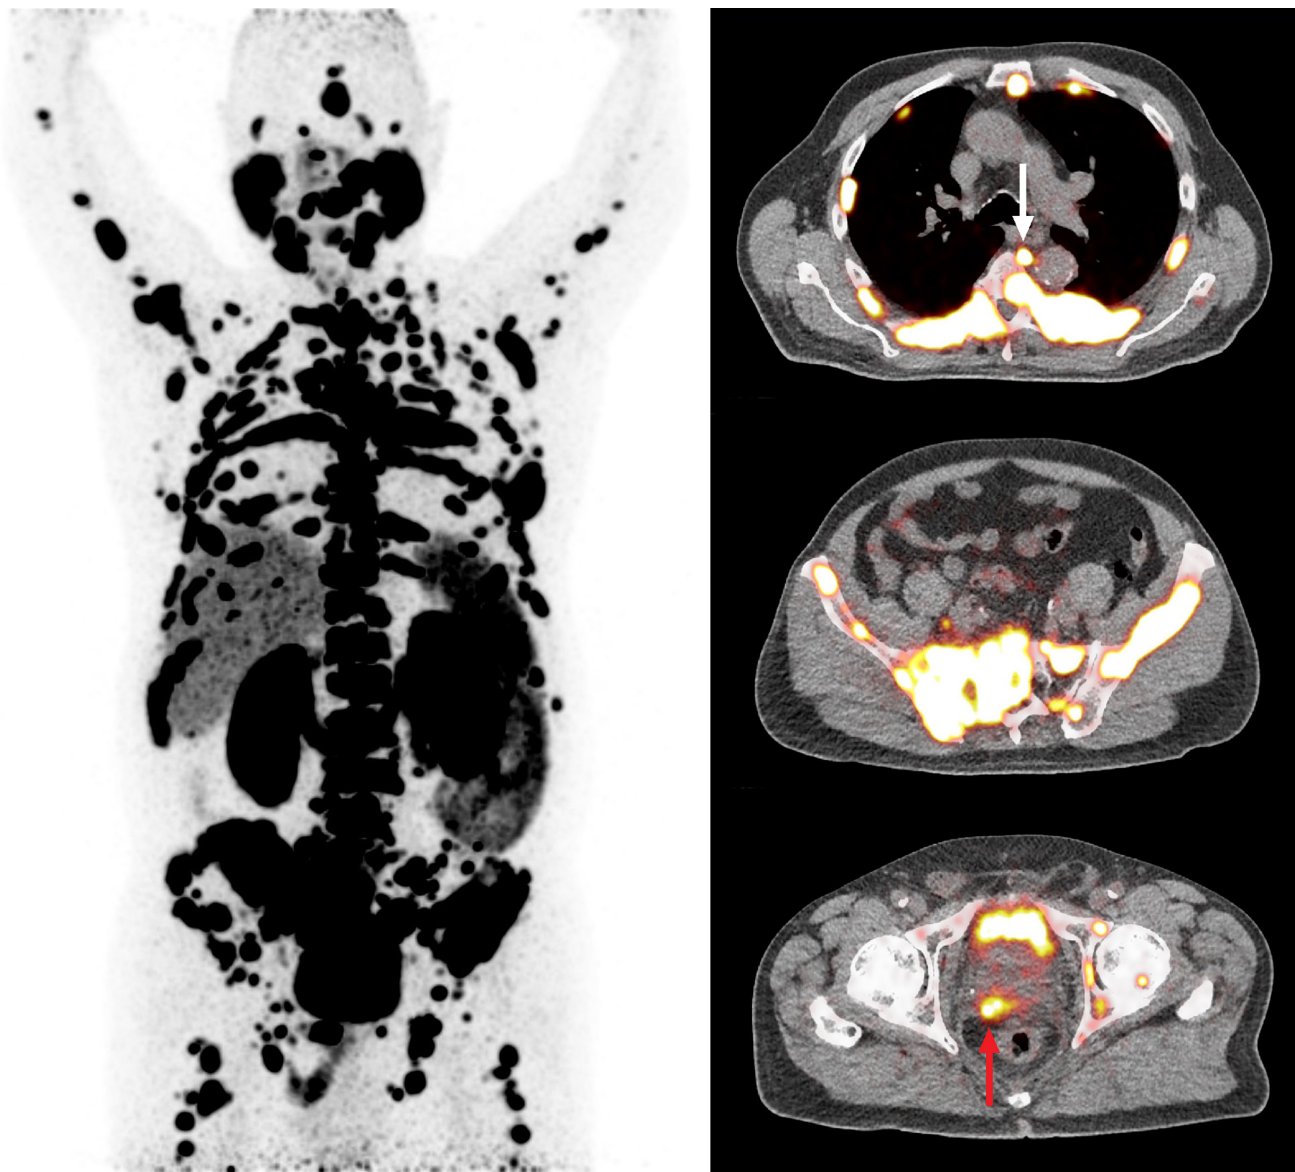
Example of ^{68}Ga -PSMA-11 imaging. A 72-year-old man with Gleason 8 prostate cancer and a PSA level of 847 $\mu\text{g}/\text{L}$. PET-CT imaging demonstrates the primary lesion in the prostate (red arrow), multiple lymph node metastases (white arrow), and extensive skeletal metastases. The scan also shows physiological activity in lacrimal glands, salivary glands, liver, spleen, kidneys, small bowels, and bladder. ^{68}Ga -PSMA-11, gallium-68-prostate-specific membrane antigen 11; PET-CT, positron emission tomography–computed tomography; PSA, prostate-specific antigen. [Color figure can be viewed at wileyonlinelibrary.com]
